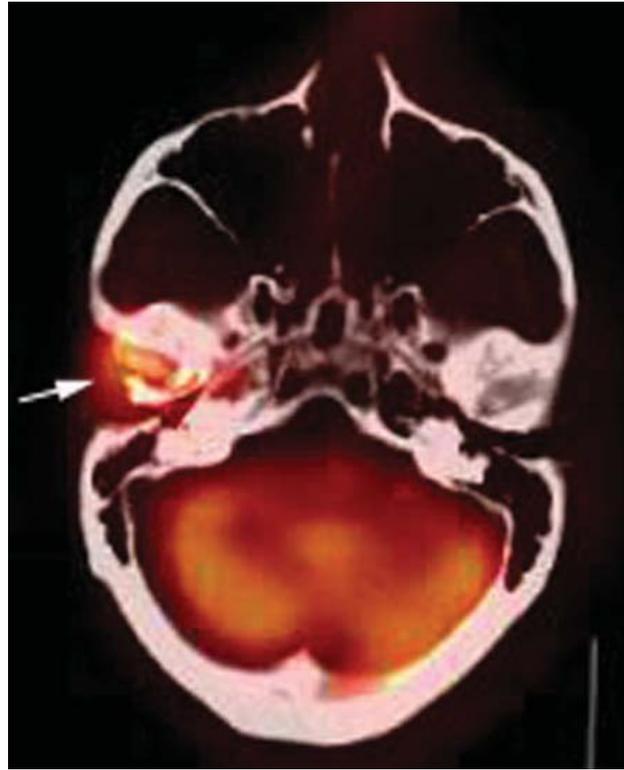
Fused positron emission tomographic and computed tomographic scan obtained seven months after treatment of squamous cell carcinoma of the right parotid gland in the patient in case 2 shows abnormal contrast material uptake in the region around the right temporomandibular joint (arrow).
